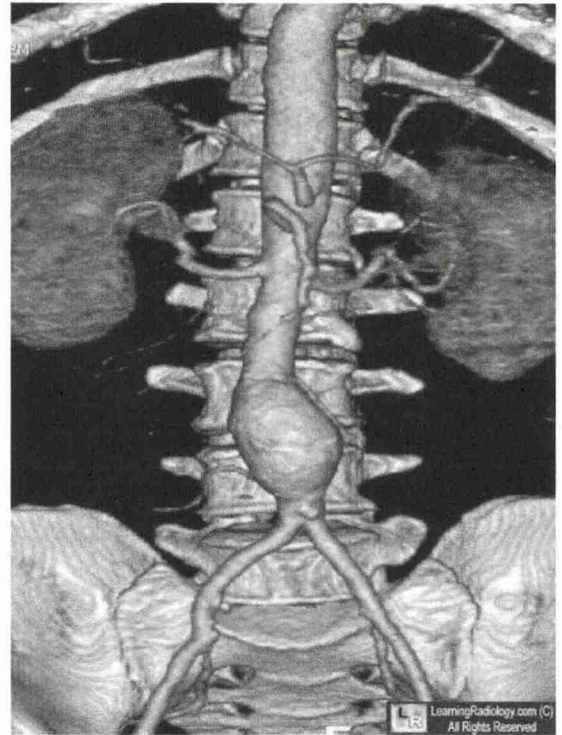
Abdominal Aortic Aneurysm CT imaging
